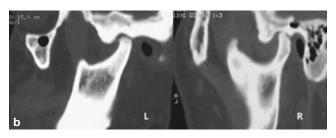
Coronal image (a) and sagittal image (b) of CT scan demonstrating bilateral joint space narrowing, erosion of left condyle and sclerosis and proliferation of bilateral condyles.
